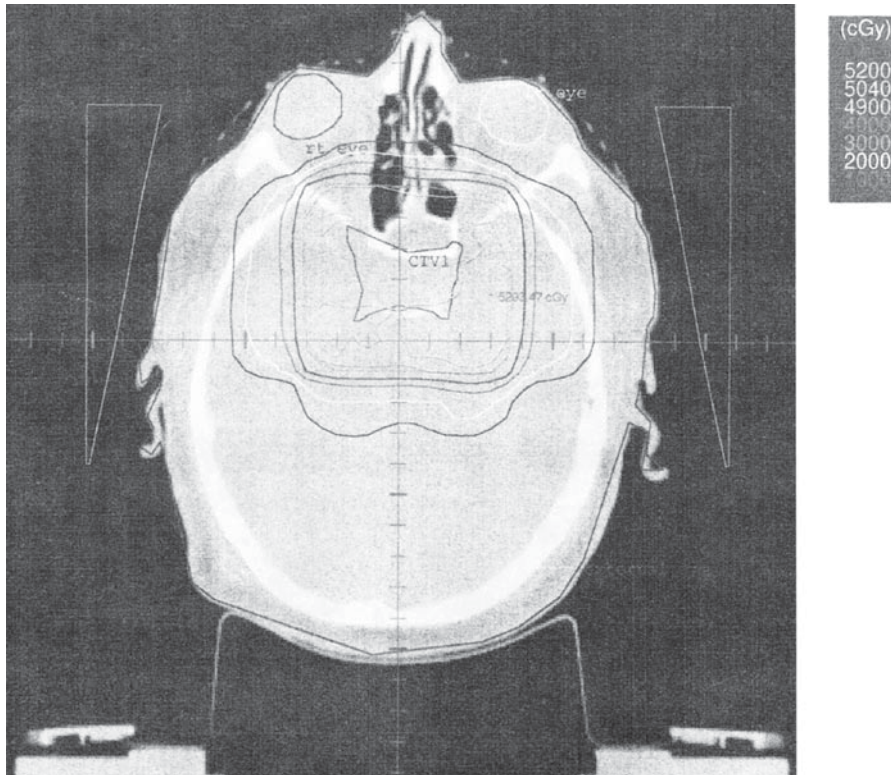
Axial CT scan image obtained for computerized treatment planning for a large non-functioning pituitary adenoma involving the right cavernous sinus. The CTV1 (clinical target volume 1) was obtained by fusion of the treatment planning CT scan images with MRI images obtained in the same patient position (with mask immobilization).
